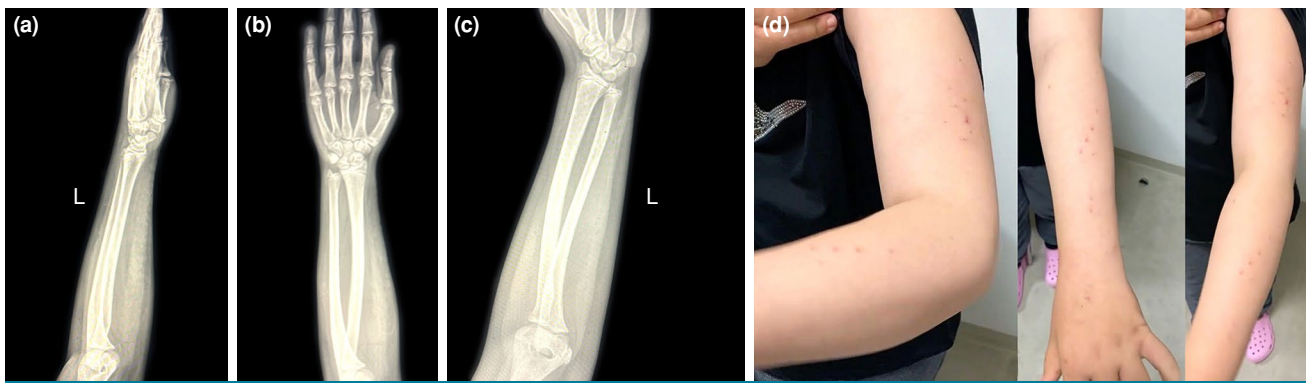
Forearm X-ray and clinical view of the case. (a) Lateral view. (b) Anteroposterior view. (c) Oblique view. (d) Clinical images of patient's forearm; post-treatment.
